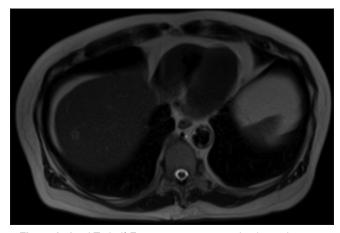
Axial T2 half-Fourier acquisition single-shot turbo spinecho image of the initial magnetic resonance imaging liver
